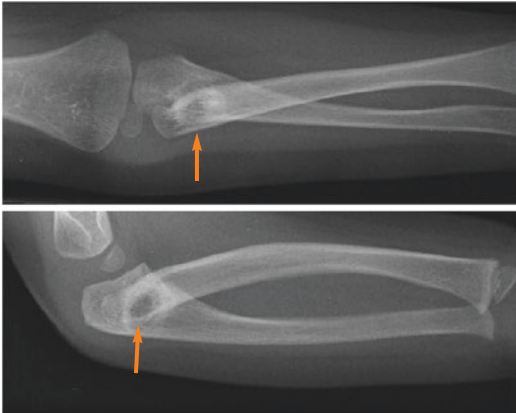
Radioulnar synostosis in the proximal part of the forearm with posterior dislocation of the radial head. (a) Anteroposterior and (b) lateral X-ray of the elbow and forearm (arrows)
